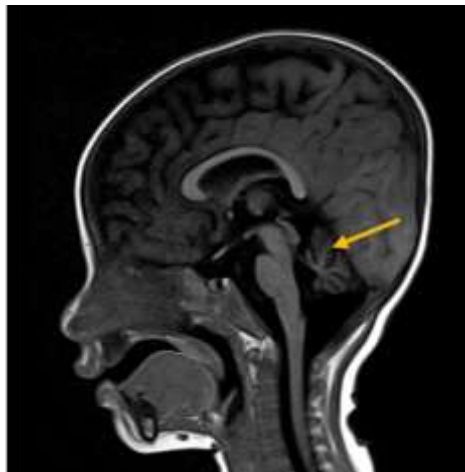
MRI Brain showing cerebellar hypoplasia
